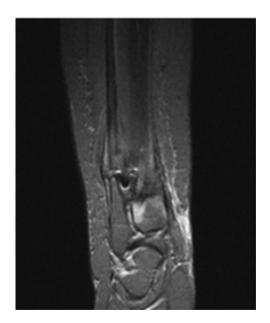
MRI shows metaphyser abscess.
